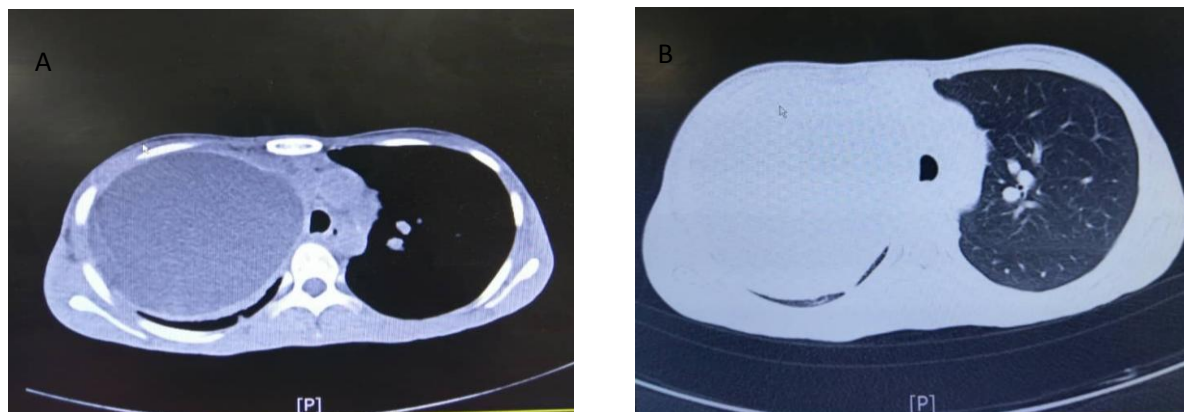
(A, B): Computed tomography scan and chest x-rays showing very large hydatid cyst
